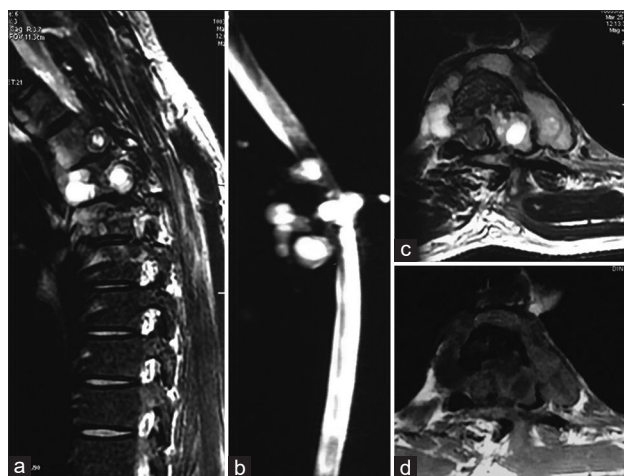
(a) Magnetic resonance imaging of the dorsal vertebra in the sagittal plane, T2 sequence showing hydatid cysts in the D4 region with partial collapse of D4 vertebra. (b) Magnetic resonance imaging of the dorsal vertebra in the sagittal plane, myelo sequence showing hydatid cysts in the D4 region. (c) Magnetic resonance imaging of the dorsal vertebra in an axial plane with T2 sequence showing hydatid cysts in the D4 region. (d) Magnetic resonance imaging of the dorsal vertebra in an axial plane, T1 sequence showing hydatid cysts in the D4 region
